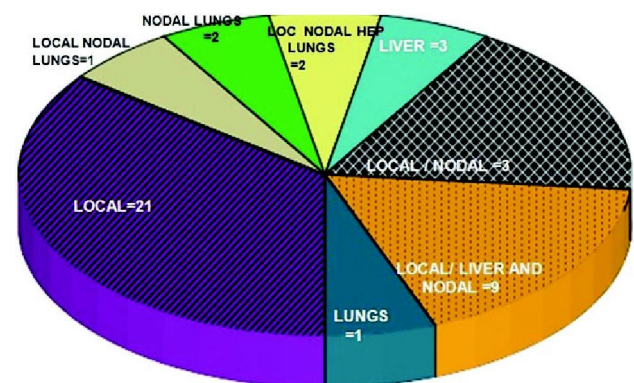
Types of recurrence based on CT findings
